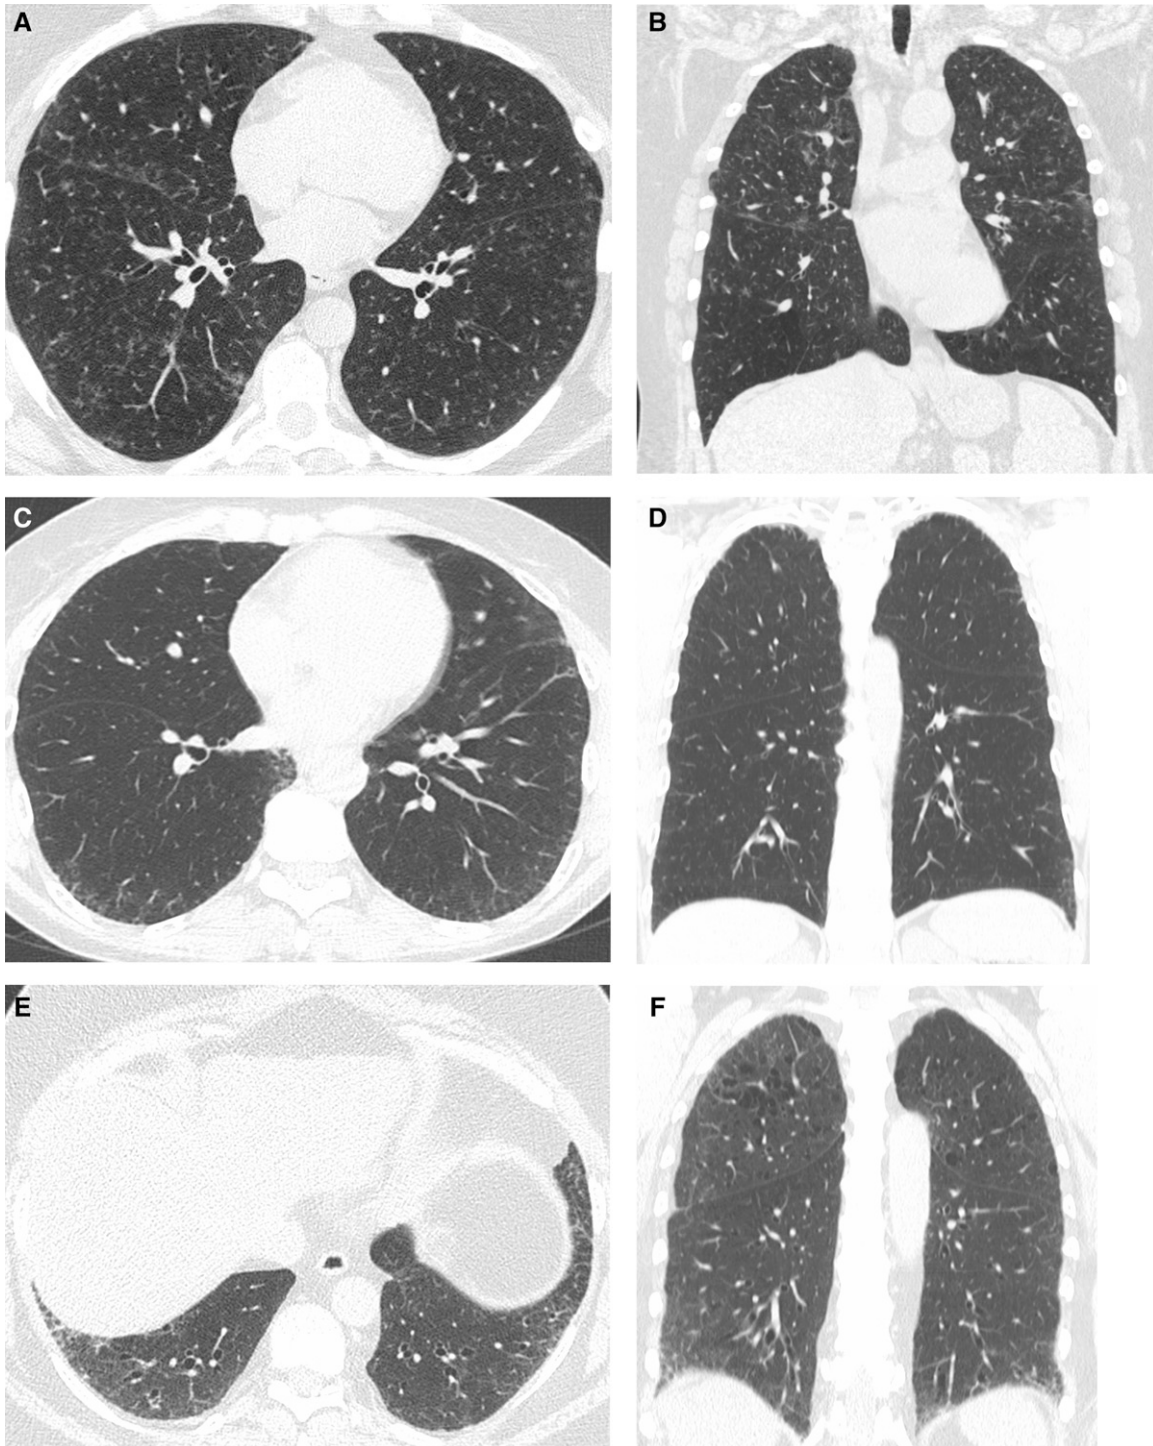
Interstitial lung abnormality (ILA) subtypes. (A and B) Nonsubpleural ILA. Axial (A) and coronal (B) images show patchy ground-glass and peribronchovascular opacities predominantly in the upper lung zones with minimal reticular opacities. (C and D) Subpleural nonfibrotic ILA. Axial (C) and coronal (D) computed tomography images show bilateral subpleural reticulations without traction bronchiectasis or honeycombing. (E and F) Fibrotic ILA. Axial (E) and coronal (F) images show bilateral subpleural reticulations with traction bronchiolectasis.
